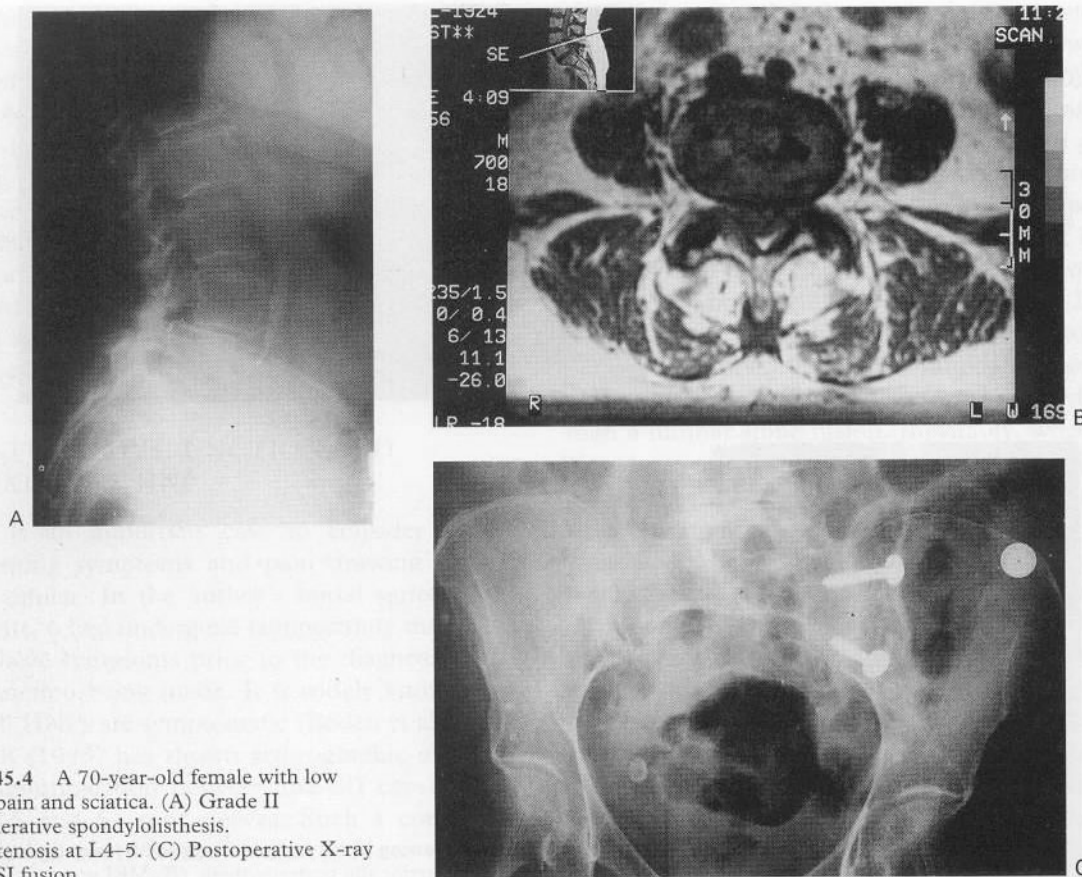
A 70-year-old female with low back pain and sciatica. (A) Grade II degenerative spondylolisthesis. (B) Stenosis at L4-5. (C) Postoperative X-ray after SIJ fusion.
